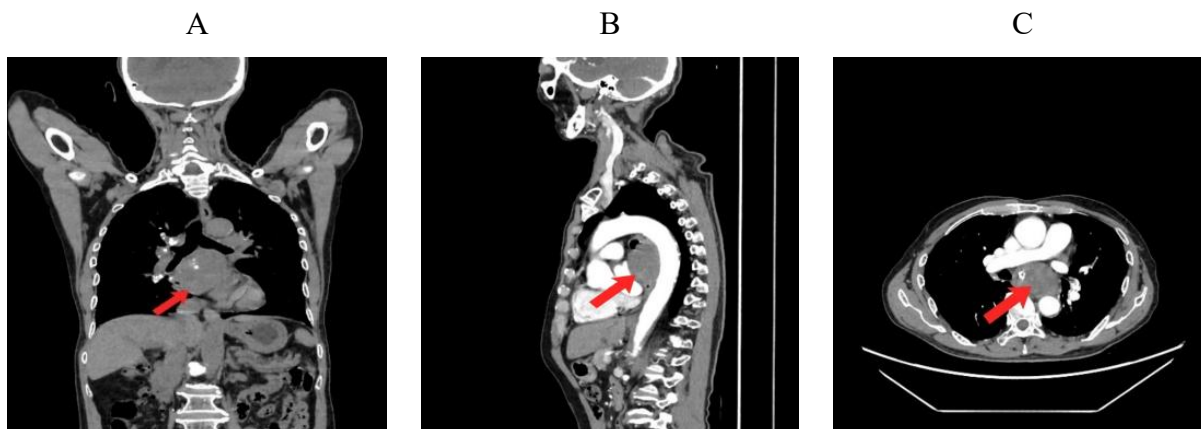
Contrast-enhanced chest CT images. (A) Coronal, (B) sagittal and (C) axial views show a 6.8 x 6.2 x 3.5 cm posterior mediastinal soft-tissue mass adjacent to the esophagus with an ill-defined tumor-organ interface.
